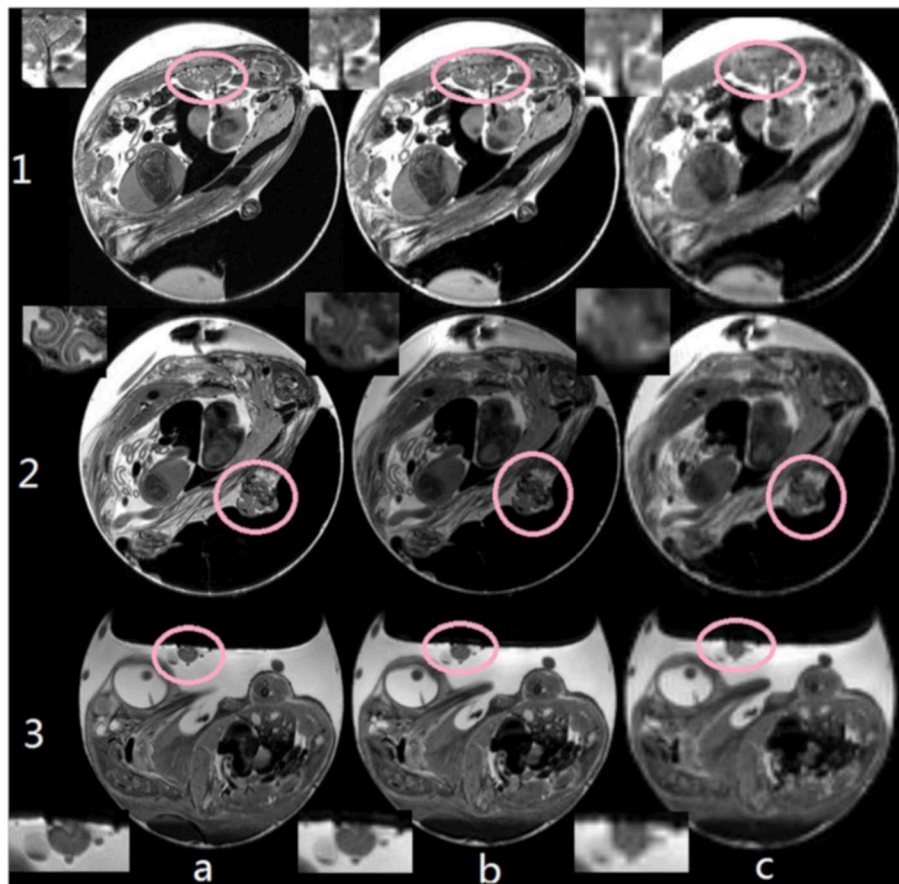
Comparison between different image resolution: (a) $77 \times 91 \mu\text{m}^2$, (b) $200 \times 200 \mu\text{m}^2$, and (c) 500×500 . With increasing resolution, details of e.g., the pulmonary veins (1), the beak (2, axial orientation), and tumor tissues (3) could be clearly resolved. Insets show details of the respective target structures. This research was originally published in NMR Biomed: High-resolution MRI analysis of breast cancer xenograft on the chick chorioallantoic membrane. Zuo et al. [61].
